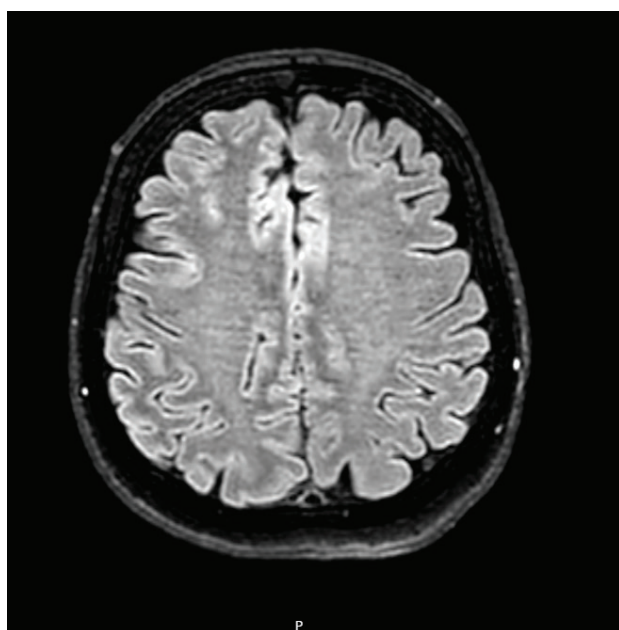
MRI flair sequence.
